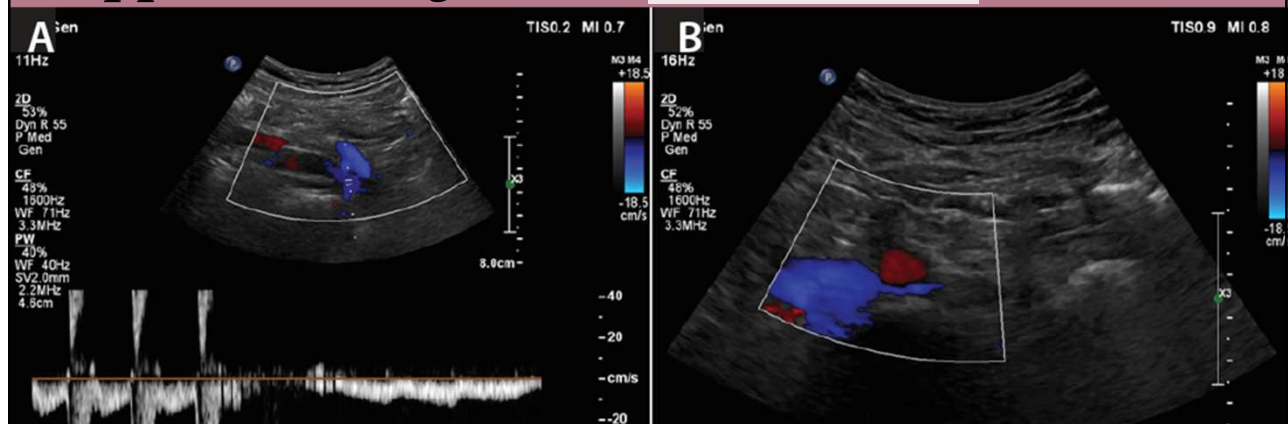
Transabdominal ultrasound imaging of the internal iliac vein with Spectral Doppler tracing demonstrating reflux.<sup>13</sup>
